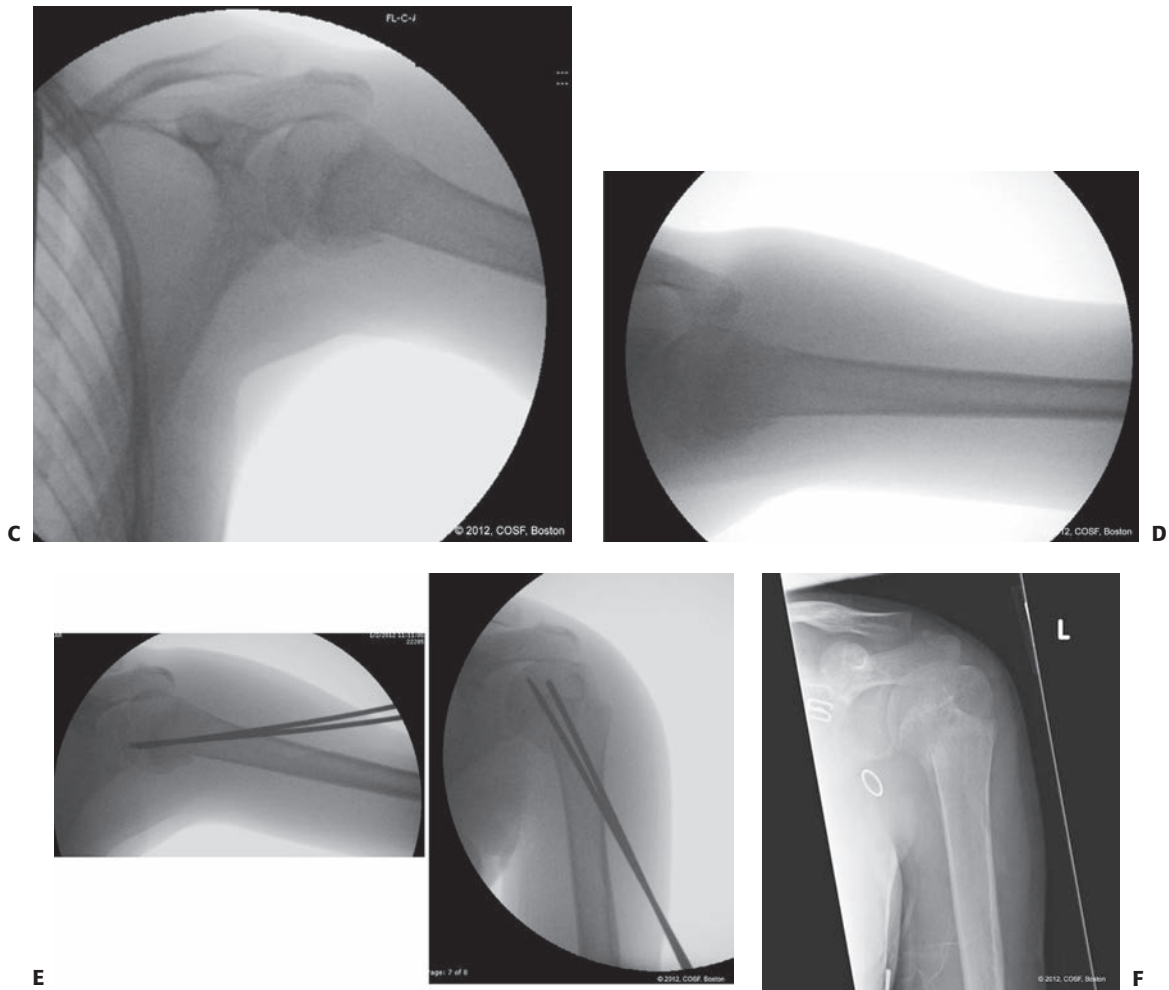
(continued) Intraoperatively, the fracture is closed reduced with traction, abduction (C) and correction of the apex anterior angulation (D). E: Postoperative alignment after percutaneous pinning. F: Follow-up radiograph demonstrates improved alignment and bony healing.
